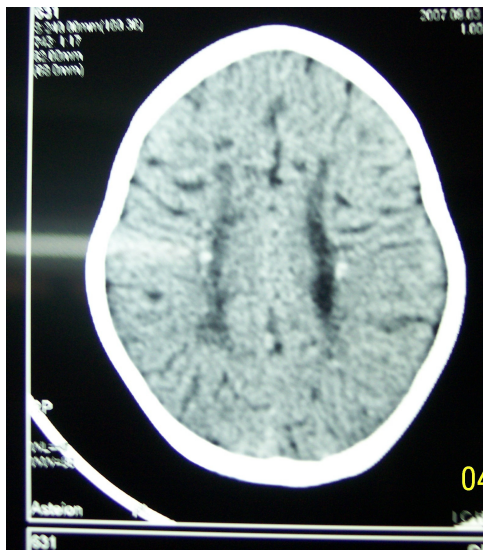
CT picture showing periventricular calcification
